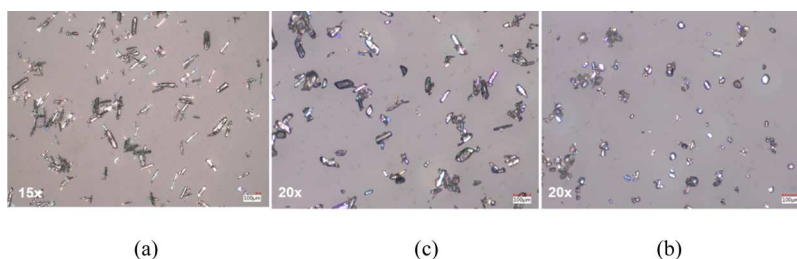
Impact of ultrasound amplitude for the following conditions: (a) recycle control, (b) 20, and (c) 80% over the course of isothermal API crystallization experiments using an external ultrasound flow cell.
